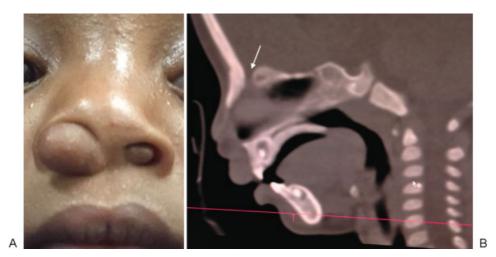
(A) Encephalocele shown protruding from both nostrils. (B) The sacs are fluid filled and extend up to a skull base defect shown on CT lateral view of the defect (white arrow) at the foremen anterior skull base connecting to the midline nasal mass. (Artwork courtesy: Dr. David Shaye.)
